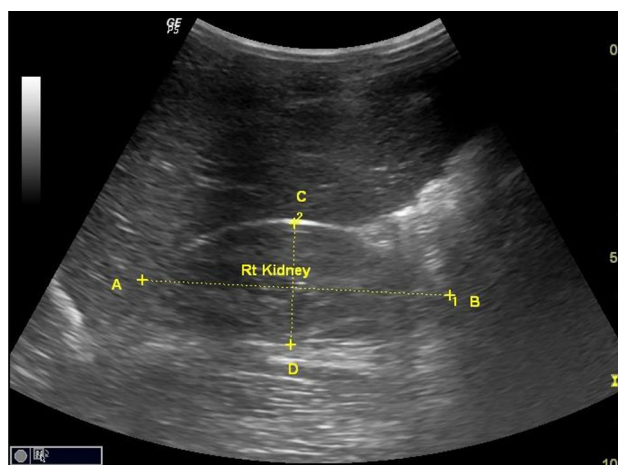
A B-mode longitudinal ultrasound image through the right kidney showing the kidney and part of the right lobe of the liver. (AB = kidney length)
